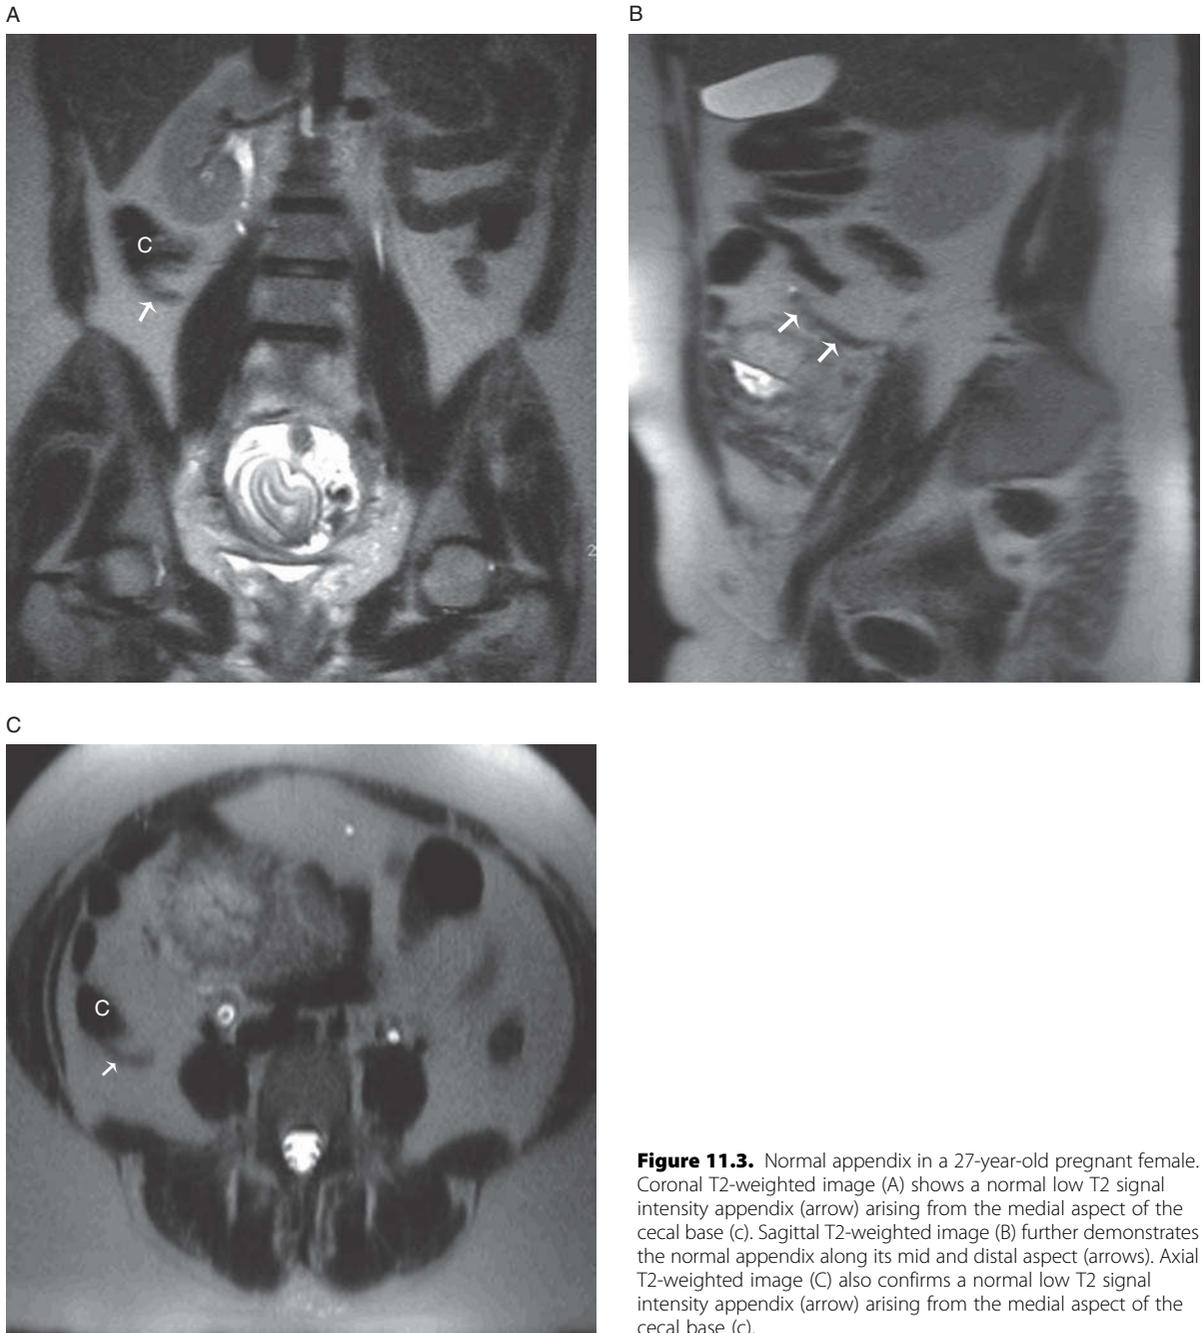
Normal appendix in a 27-year-old pregnant female. Coronal T2-weighted image (A) shows a normal low T2 signal intensity appendix (arrow) arising from the medial aspect of the cecal base (c). Sagittal T2-weighted image (B) further demonstrates the normal appendix along its mid and distal aspect (arrows). Axial T2-weighted image (C) also confirms a normal low T2 signal intensity appendix (arrow) arising from the medial aspect of the cecal base (c).
